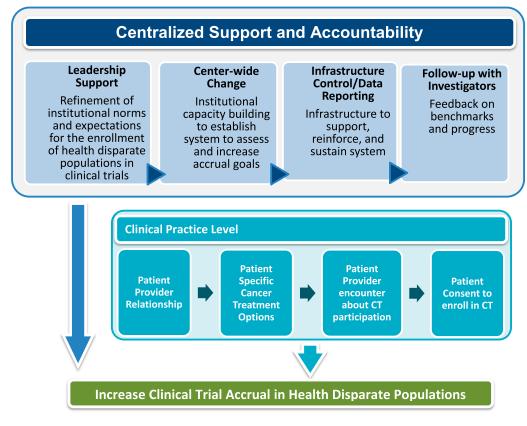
Moores Cancer Center approach and framework for clinical trial accrual. There is a need to centralize recruitment of health disparate populations to clinical trials, have organizational accountability, and have continued monitoring. Structural changes are needed on four levels: (1) leadership support, (2) center-wide policy change, (3) infrastructural process and control, and (4) follow-up with clinical investigators. CT, XXX.
